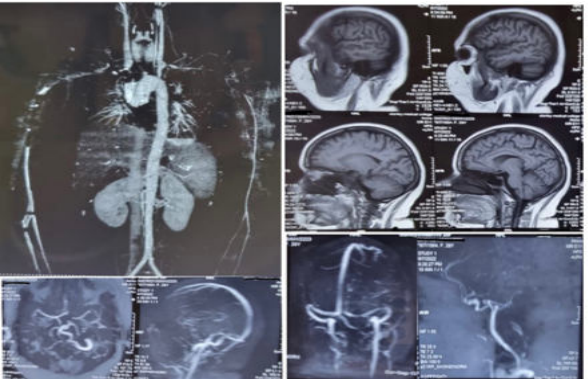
CECT Aortogram of Upper limb (upper left) , MRI Brain sagittal T1 weighted image (upper right) and MR Angiogram and Venogram
